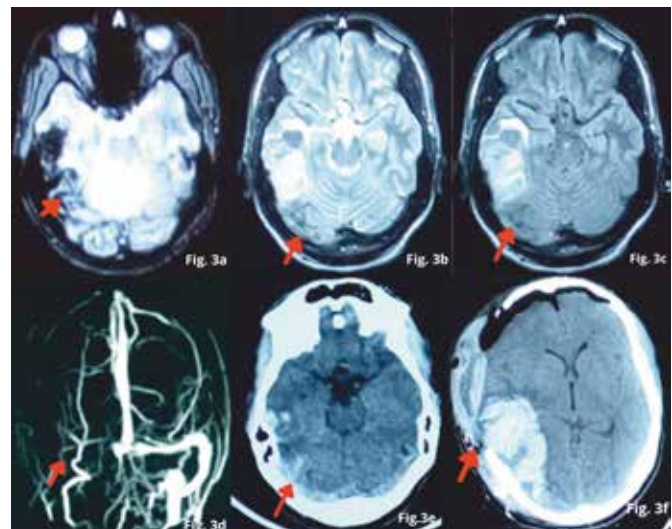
(a to f). (a) Axial GRE Image Shows Abnormal Blooming in Right Transverse Sinus and Adjacent Right Temporo Parietal Lobe with Widening of Sinus Consistent With Sinus Thrombosis With Hematoma. (b and c) Axial T2W and Flair Images Shows Absence of Flow Void in Right Transverse and Sigmoid Sinus. (d) Frontal MIP Image From Coronal TOF MRV Shows Lack of Flow in Right Transverse and Sigmoid Sinus. (e) Axial Unenhanced CT Image Shows Area of Abnormal Hyper Attenuation in Right Transverse and Sigmoid Sinus Consistent with CVT. Also Noted Right Temporal Shift with Mild Edema. (f) Axial Unenhanced CT Image Shows Right Front Parietal Craniotomy Defect with Large Intraparenchymal Hematoma and Subgaleal Hemorrhage with Pneumocephalus
